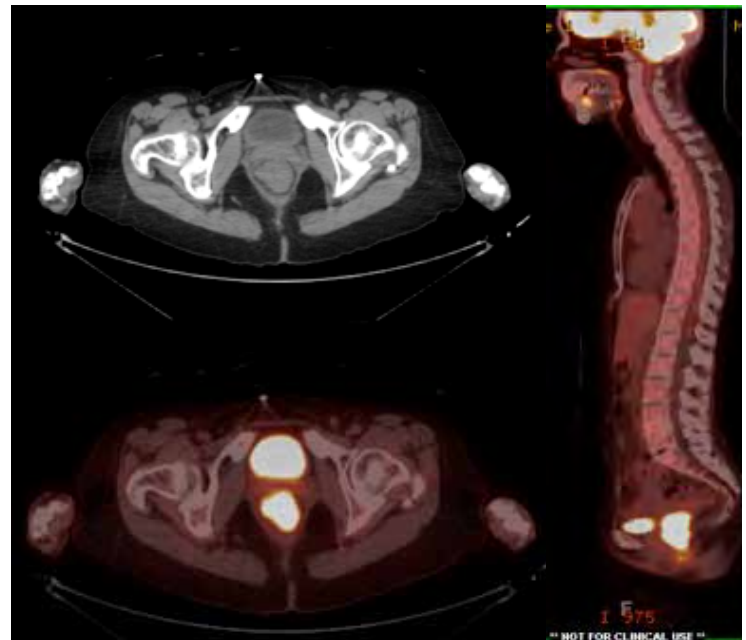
Computed tomography and positron emission tomography scans showing rectal lesion.
